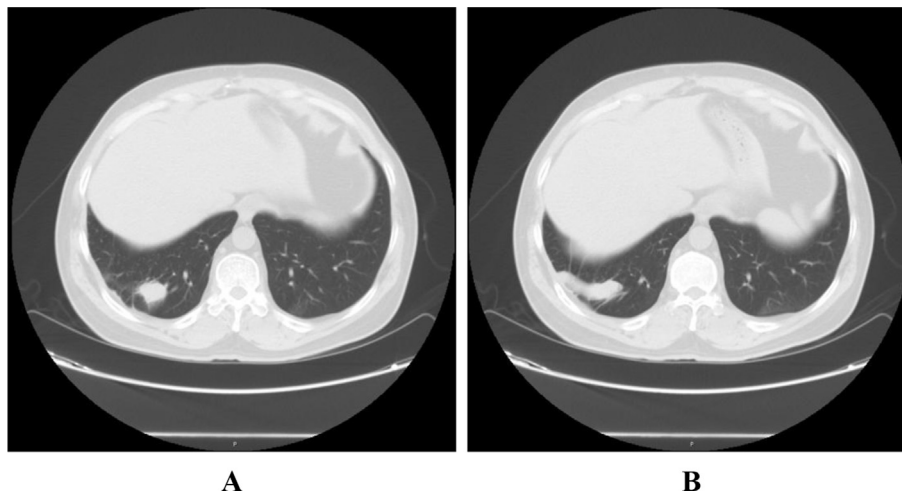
A 47-year-old man with pulmonary paragonimiasis in right lower lobe. Plain CT scan of chest shows a pulmonary nodule (A), and a tubular opacity extending from the pleura to the lung, which suggests a migration track (B).
